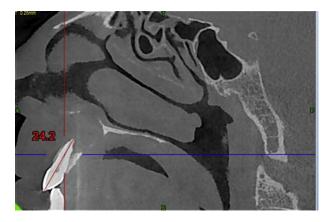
WL measurements by using CBCT scans.
